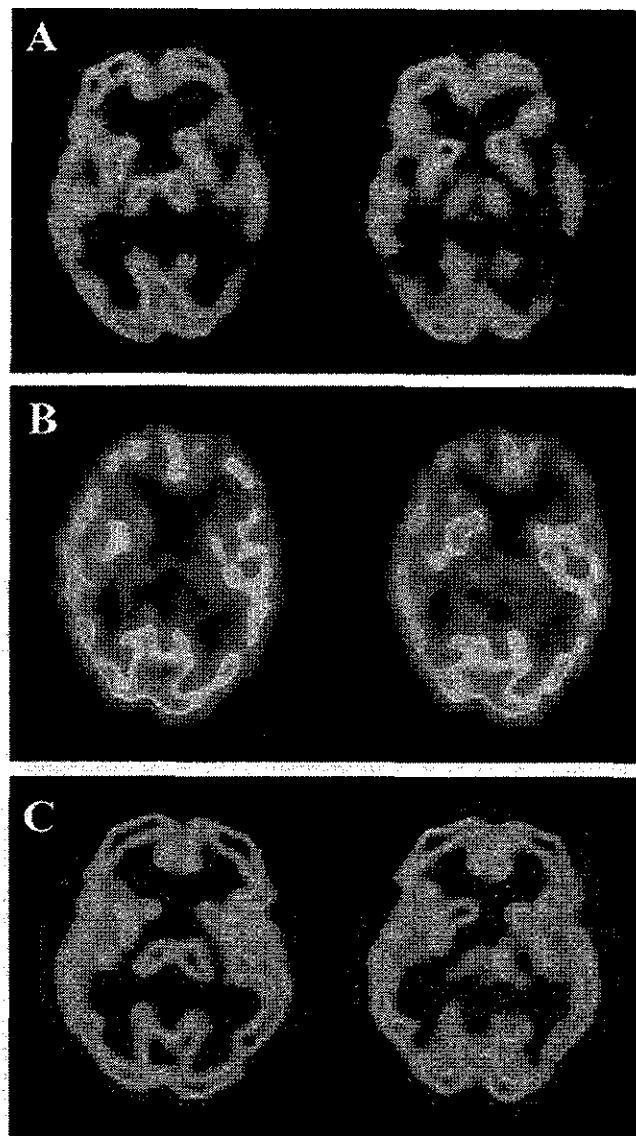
SPECT of cerebral blood flow (CBF) using ^{99m}Tc -ethyl cysteinate dimer in Patient 2 at 16 months after the onset (A), Patient 8 at 7 months after the onset (B), and a normal control subject who was a 67-year-old man without neurologic abnormality or cognitive decline (C). SPECT shows reduction of CBF in the bilateral temporal cortex in Patient 2 (A) and in the bilateral thalamus as well as the temporal cortex in Patient 8 (B) compared with the normal control subject (C).
